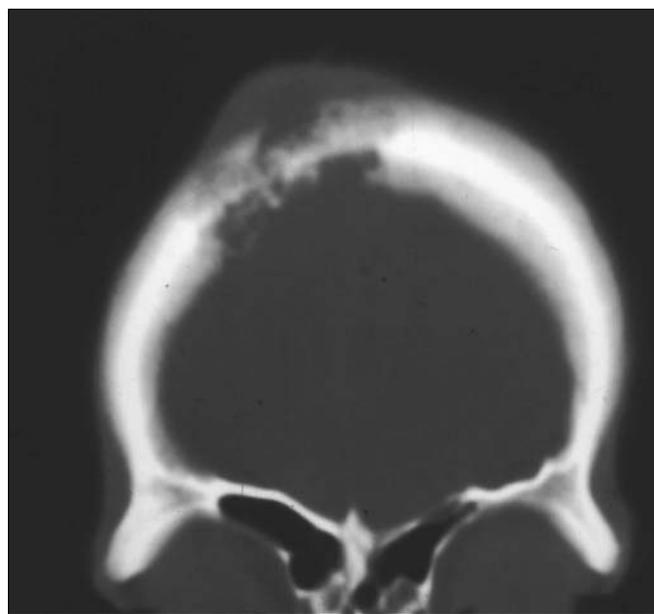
Case 4. CT scan shows soft-tissue swelling of the scalp adjacent to the area of osteomyelitis of the skull and inflammation of the meninges in the same region.
